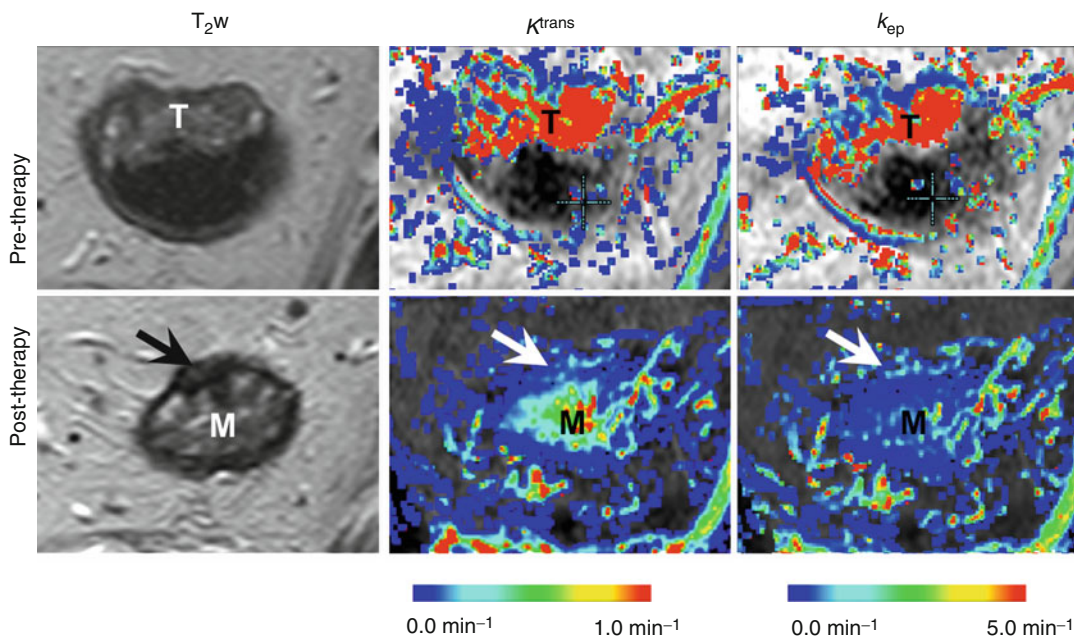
DCE-MRI assessment of chemoradiotherapy-induced changes in the tumor vasculature. Representative T2-weighted images (T_{2w}) and maps of the endothelial transfer coefficient (K^{trans}) and the exchange rate constant (k^{ep}) obtained for a rectal cancer patient at the primary staging (*upper panel*) and after 8 weeks' interval following the neoadjuvant chemoradiotherapy (*lower panel*).
